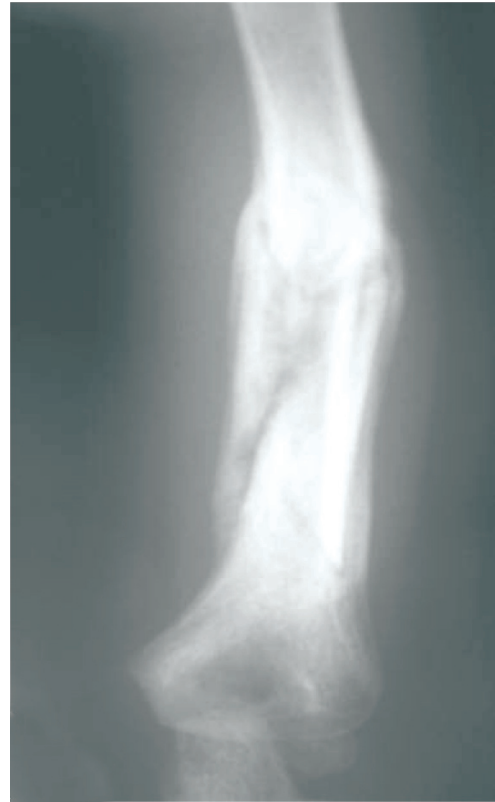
(Case 2) X-ray showing united fracture
